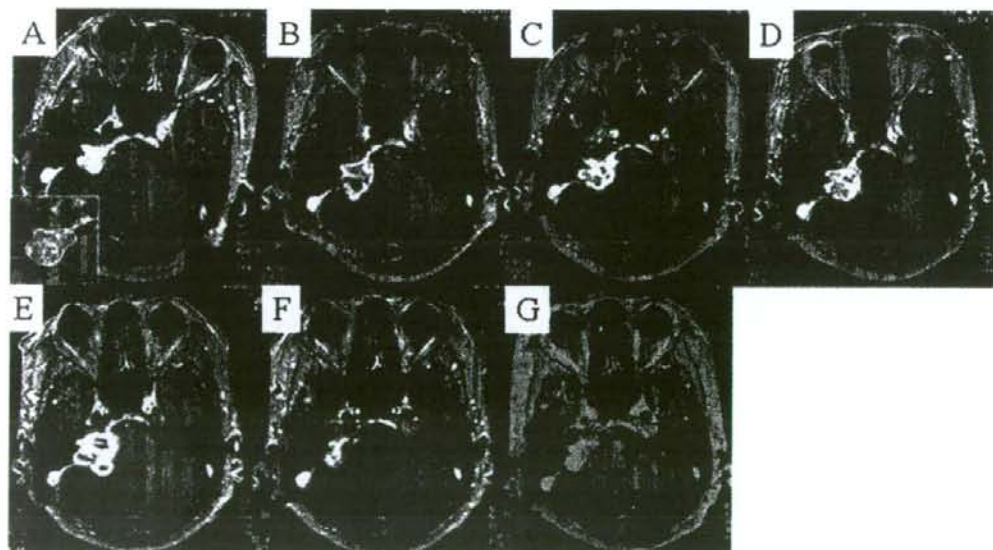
Serial contrast-enhanced axial T1-weighted MR images obtained in a 64-year-old woman with a right VS who underwent GKS. A: Dose-planning image for a right-sided VS. Line (inset) indicates the 50% isodose curve. The initial tumor volume was 3.8 cm³. B: On an MR image obtained 3 months later, there was an 81% expansion (6.9 cm³) with central low intensity. C: Image obtained 6 months post-GKS, demonstrating a 97% expansion (7.5 cm³). D: Image obtained 9 months post-GKS, showing a 105% expansion (7.8 cm³). E: Image obtained 15 months post-GKS, demonstrating maximum expansion (276%, 14.3 cm³). F: Image obtained 4 years post-GKS, showing shrinkage to nearly the initial size (3.7 cm³). G: Image obtained 6 years post-GKS, showing remarkable tumor regression (3.1 cm³).
